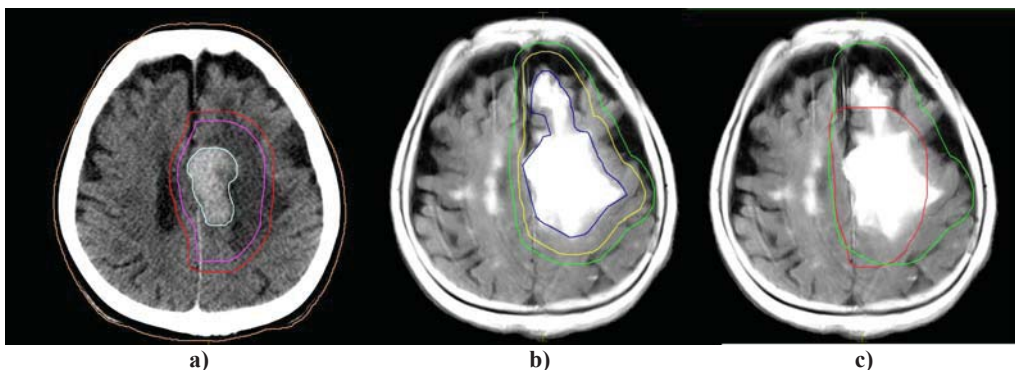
a) Computed tomography (CT) image with gross tumor volume (GTV), clinical target volume (CTV) and planning target volume (PTV); b) Magnetic resonance imaging (MRI) T2 sequence with GTV, CTV and PTV; c) Comparison between PTV according to CT (red line) and MRI (green line).
